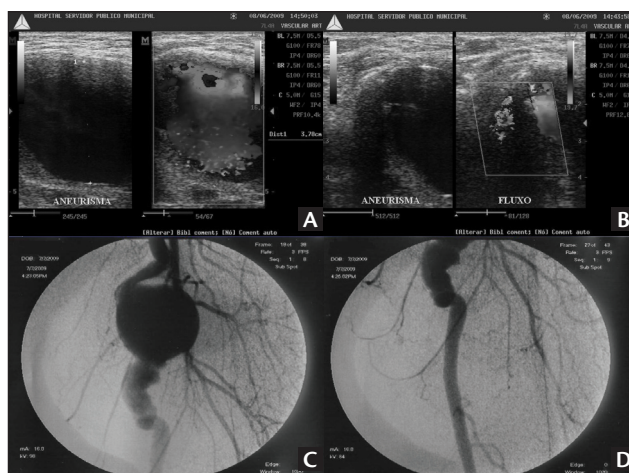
Diagnostic examinations. (A) Color Doppler ultrasound showing cross-sectional vein graft aneurysm; (B) Longitudinal view of the aneurysm proximal neck; (C) arteriography of the left lower limb showing true vein graft aneurysm at the left superficial femoral artery; (D) details of the true vein graft aneurysm distal neck.
